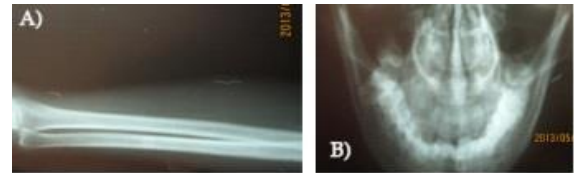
X-rays of needles (shown by arrows) in limbs and face.
